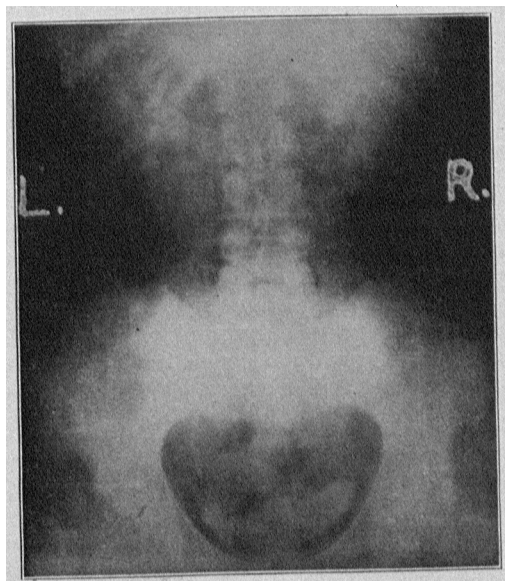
Radiograph with 20 per cent. argyrol. Left pelvis normal; lower right pelvis with tongue-like shadows at lower part; upper right pelvis very faint.
